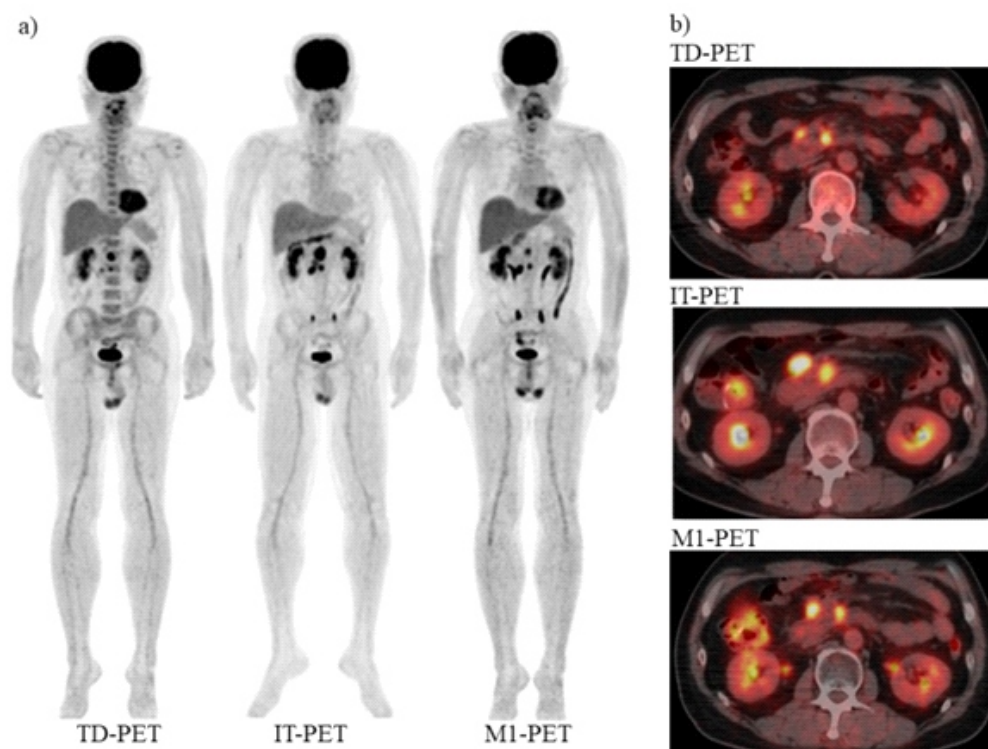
Male, 52 years old, with R/R DLBCL received lisocabtagenemaraleucel. a) Maximum intensity projection (MIP) of baseline TD-PET before bridging therapy showing several areas of intense  $^{18}\text{F}$ -FDG uptake in abdominal, pelvic, right inguinal, and bilateral leg regions. IT-PET scanning performed before CAR-T therapy revealed complete resolution of abnormal metabolic activity with an objective response of CMR, while M1-PET performed one month after CAR-T infusion showed continuance of no abnormal uptake, with an objective response of CMR. b) TD-PET image showing multiple swollen para-aortic lymph nodes with intense  $^{18}\text{F}$ -FDG uptake. IT-PET findings indicated a decreased number of nodes with vanishing  $^{18}\text{F}$ -FDG uptake, while M1-PET showed a continuance of no abnormal uptake.
